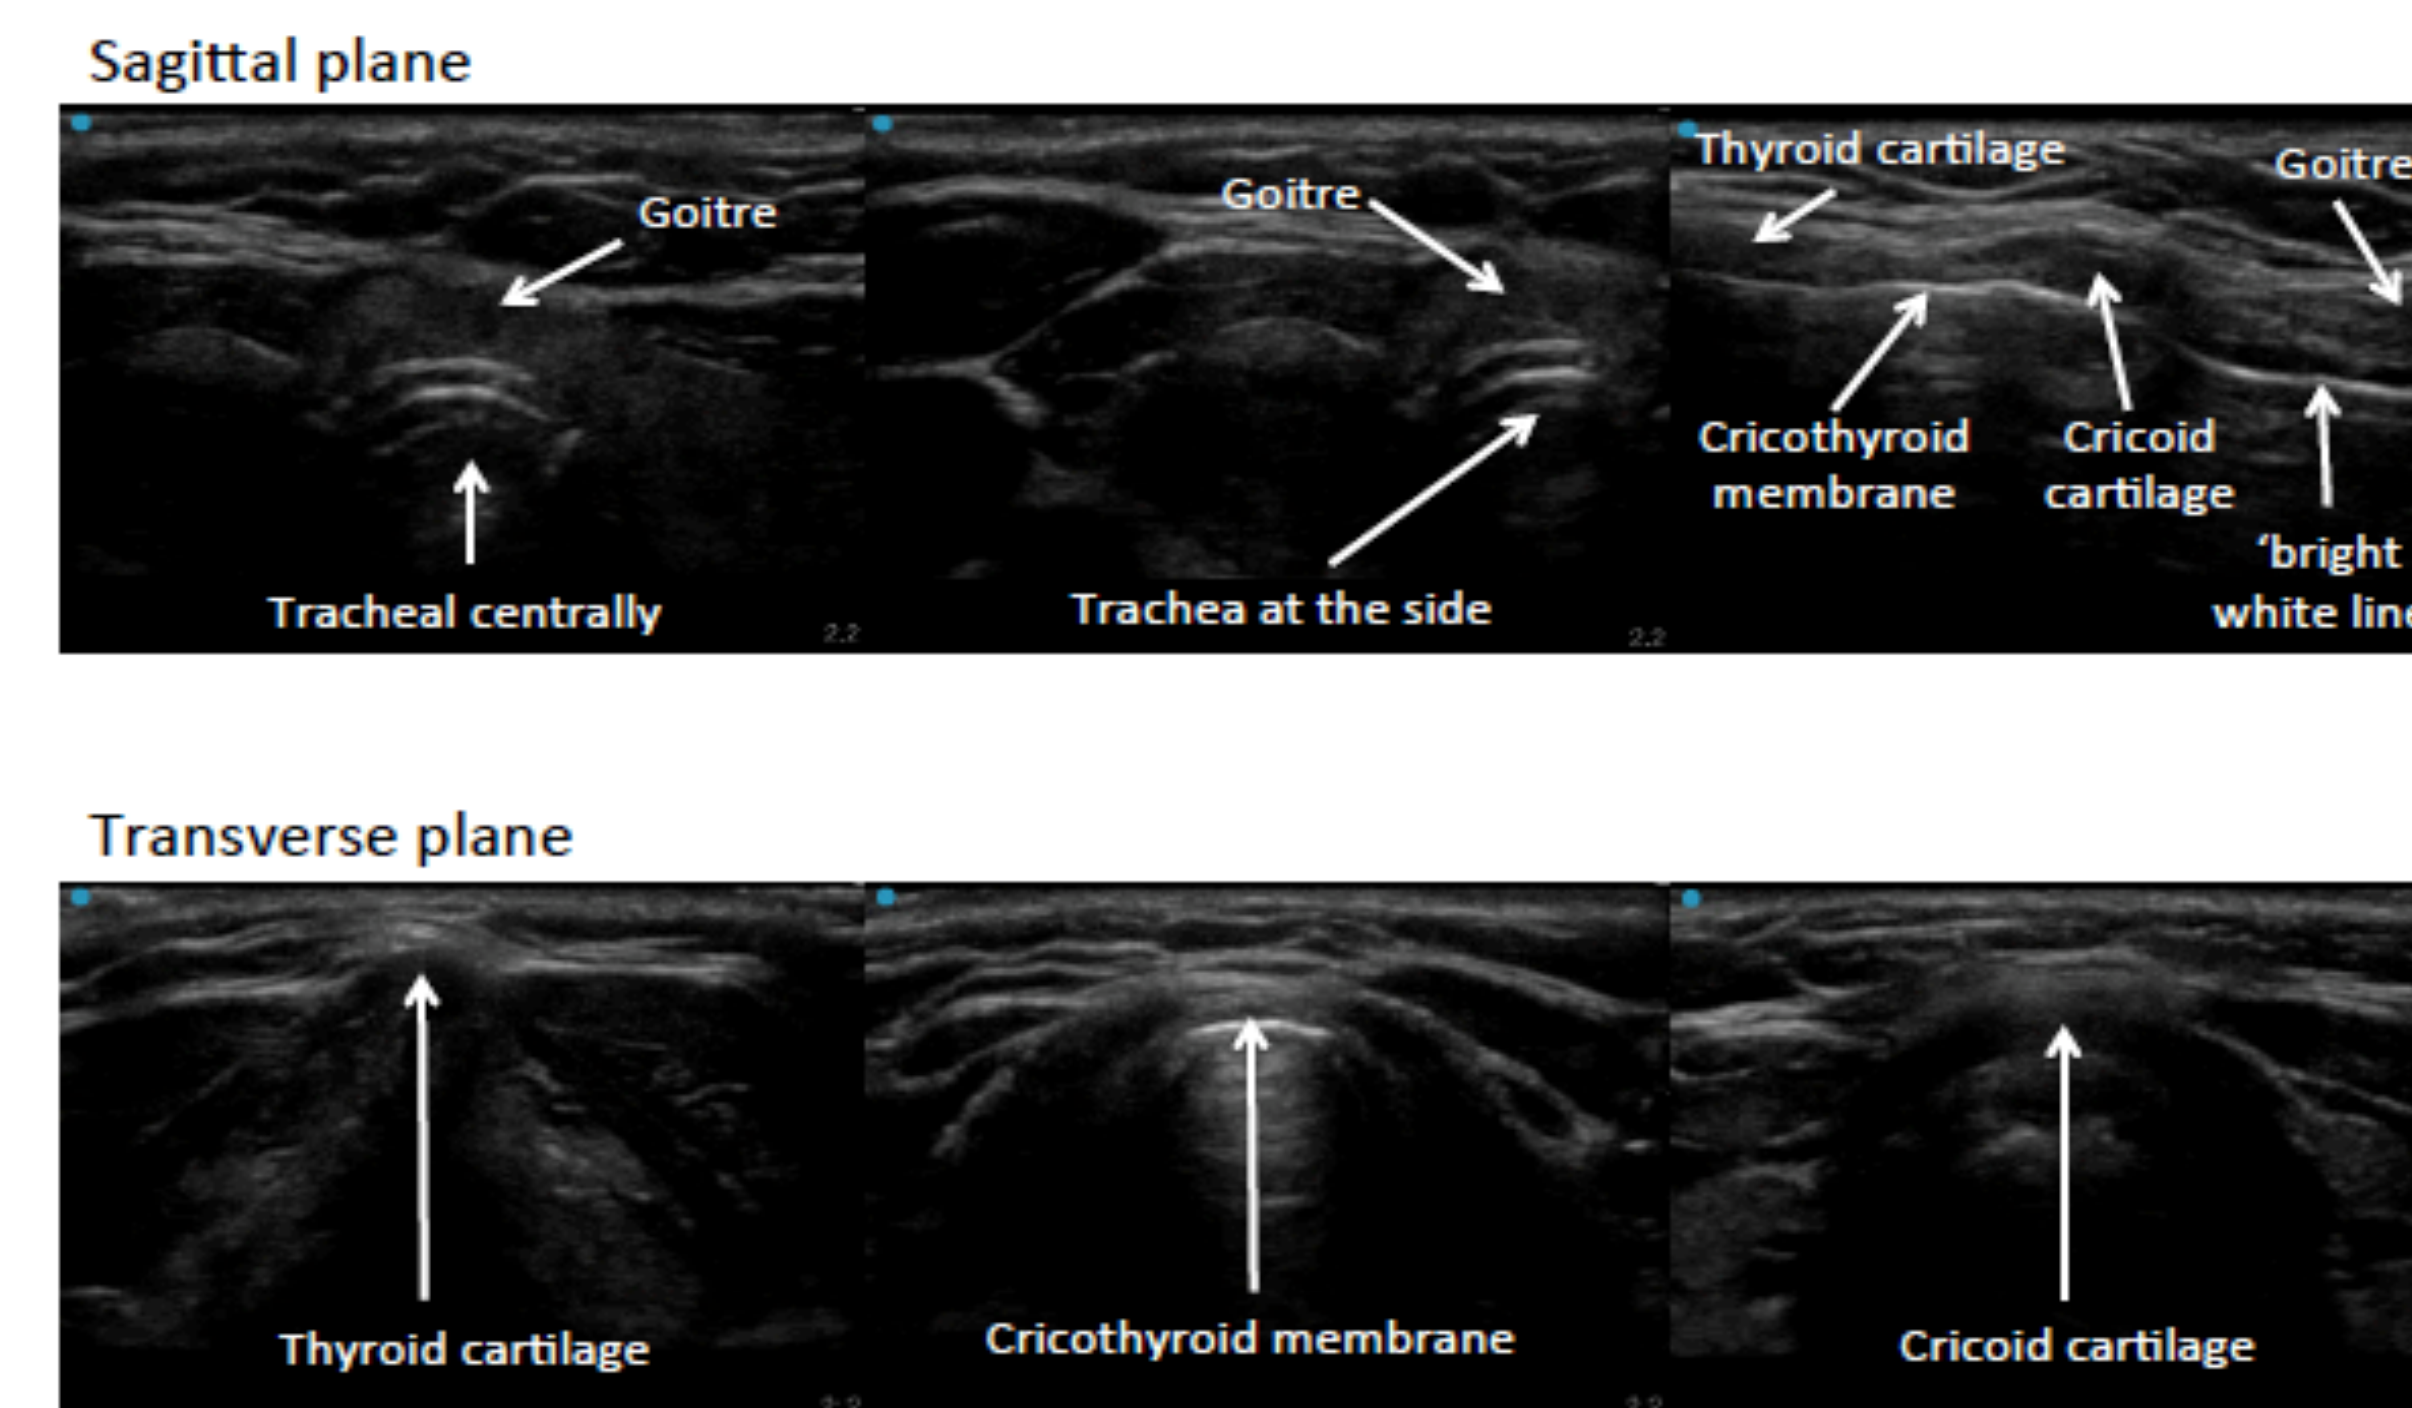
Ultrasound images of Subject B
